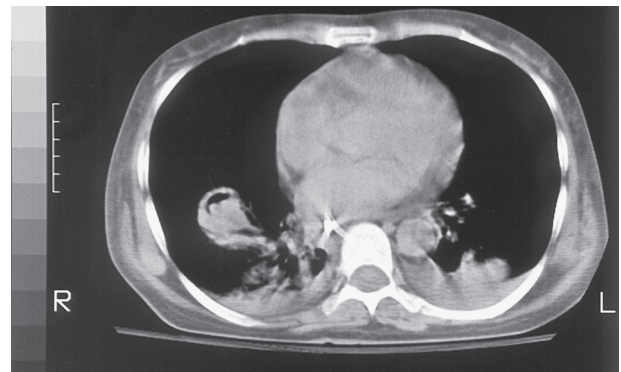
■ Computed tomography scan demonstrating an aspergilloma involving the right lower lobe.
